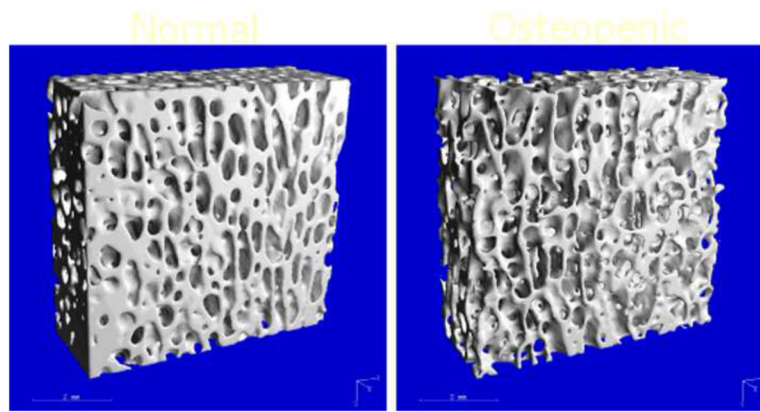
μ CT-measured trabecular bone structure, 34 μ m resolution. Left is the normal bone; right is the sample with low bone density.
